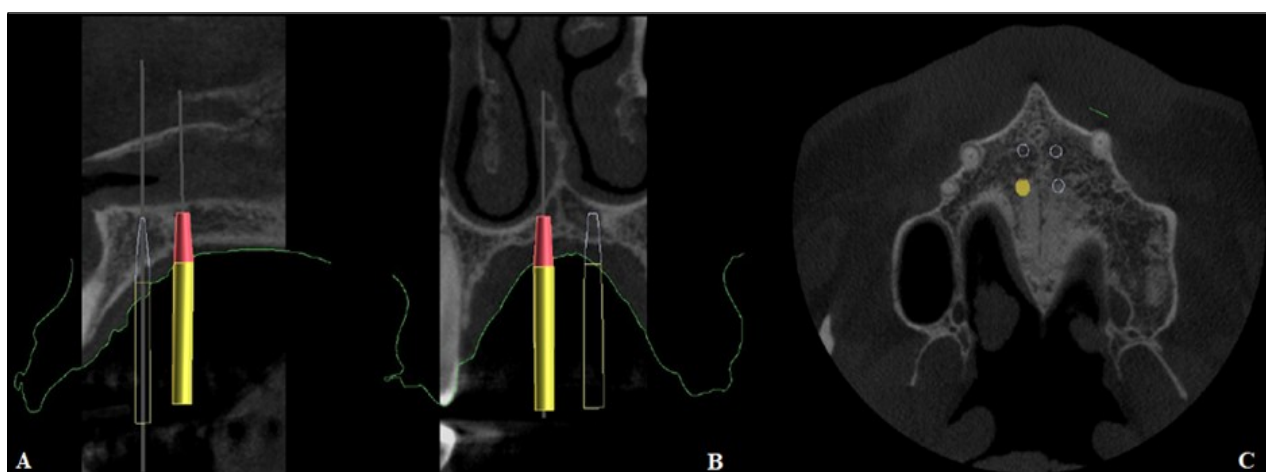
Positioning of the mini-implants on CBCT, A. Sagittal section, B. Coronal section, C. Axial section
